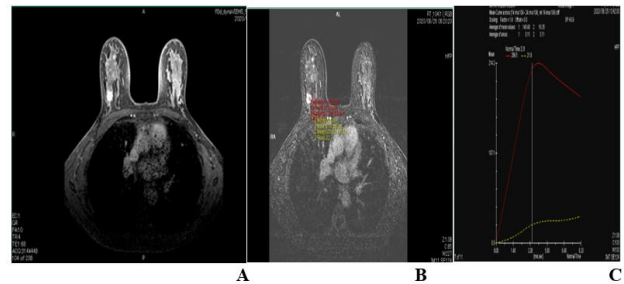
DCE-MRI axial post-contrast (A) Right UOQ rounded speculated mass lesion show homogenous enhancement, Kinetic curve (B) and (C) Rapid initial rise with wash out delayed phase.
